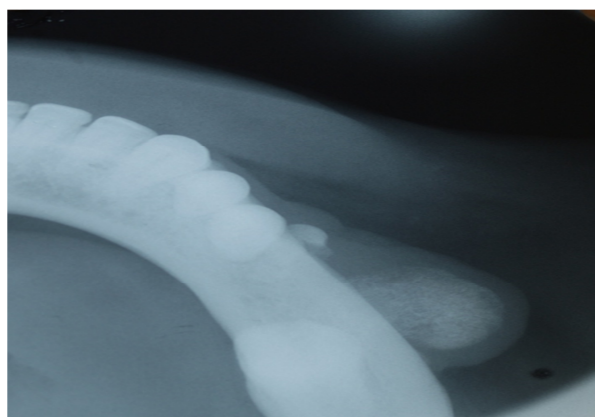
Radiographic view of the same case
